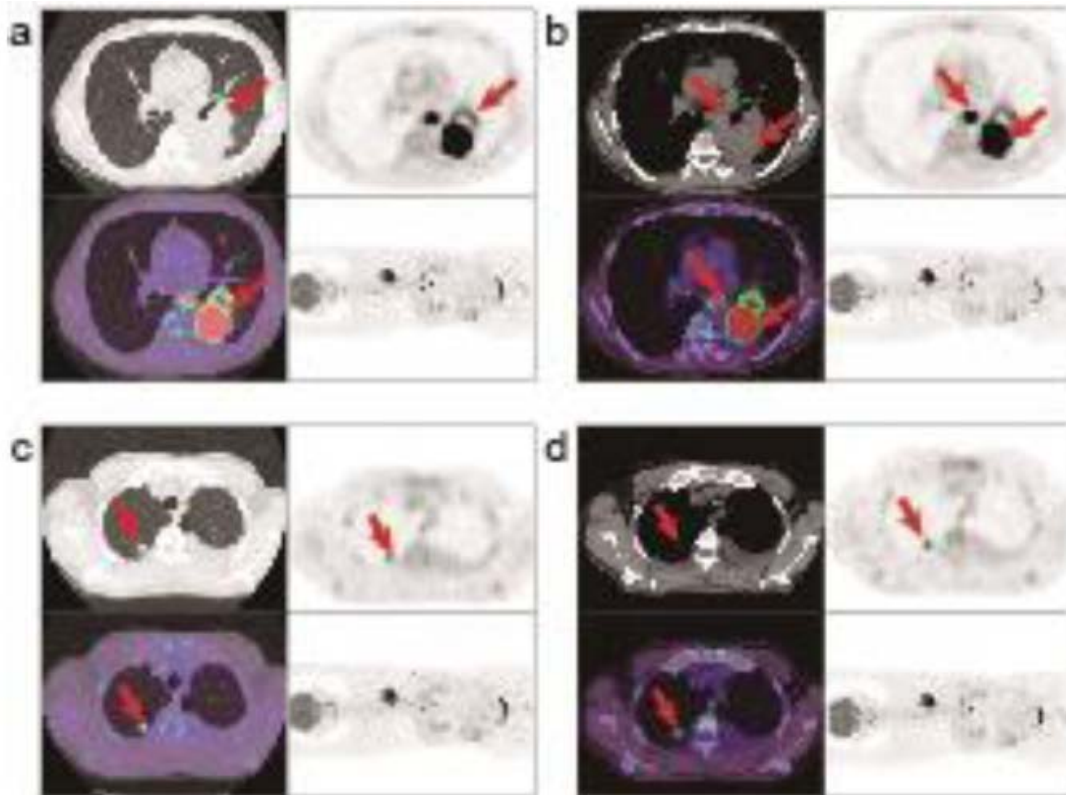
PET-CT manifestations of new on-set lung lesions in patient 1. a-b. Elevated glucose metabolism (a) and positive somatostatin receptor (b) in the left thoracic lesions. c-d. Elevated glucose metabolism (c) and weakly positive somatostatin receptor (d) in the lesion in the right upper lung.
